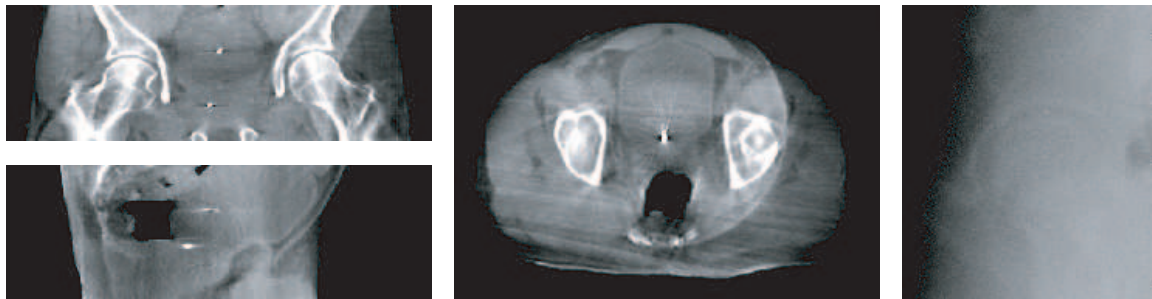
CBCT image slices of a pelvic area of a prostate cancer patient (*left and middle*) and a corresponding fluoroscopic/kV x-ray projection image (*right*).
